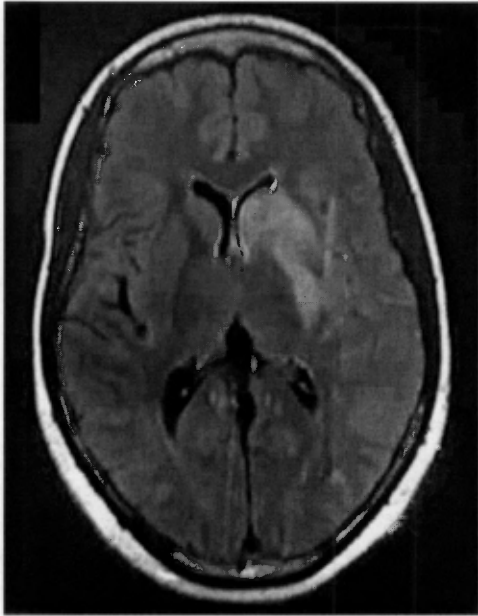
Case No.1's MRI Scan (Hyperintensity in the Head of the Left Caudate Nucleus)
